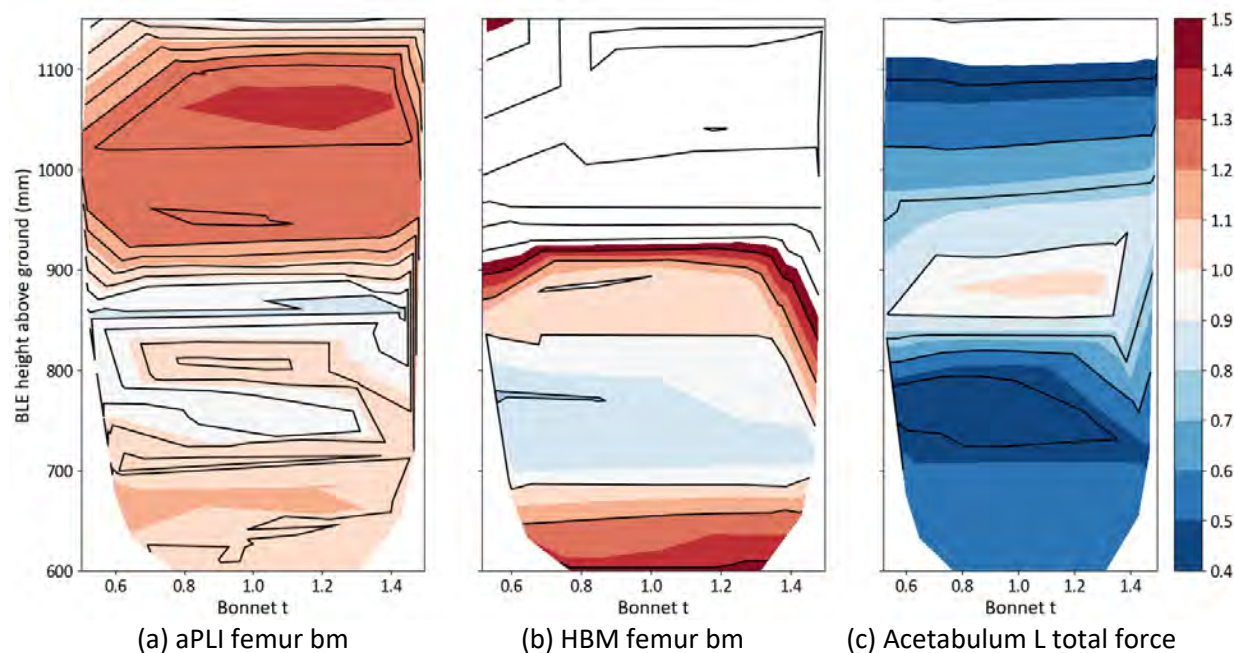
Normalised maximum injury values at test position Y+600 for the SUV by varying the exterior sheet thickness of the bonnet and the shooting height of the impactor (converted to BLE height above ground).
